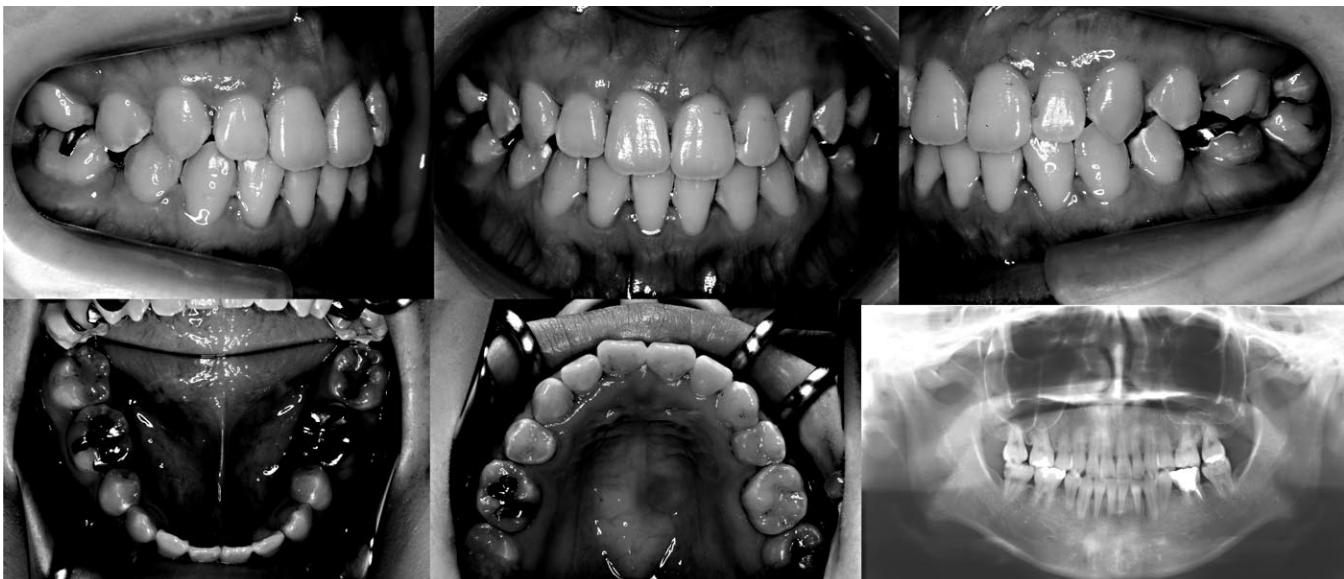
Intraoral photographs and panoramic radiographs after active treatment.
